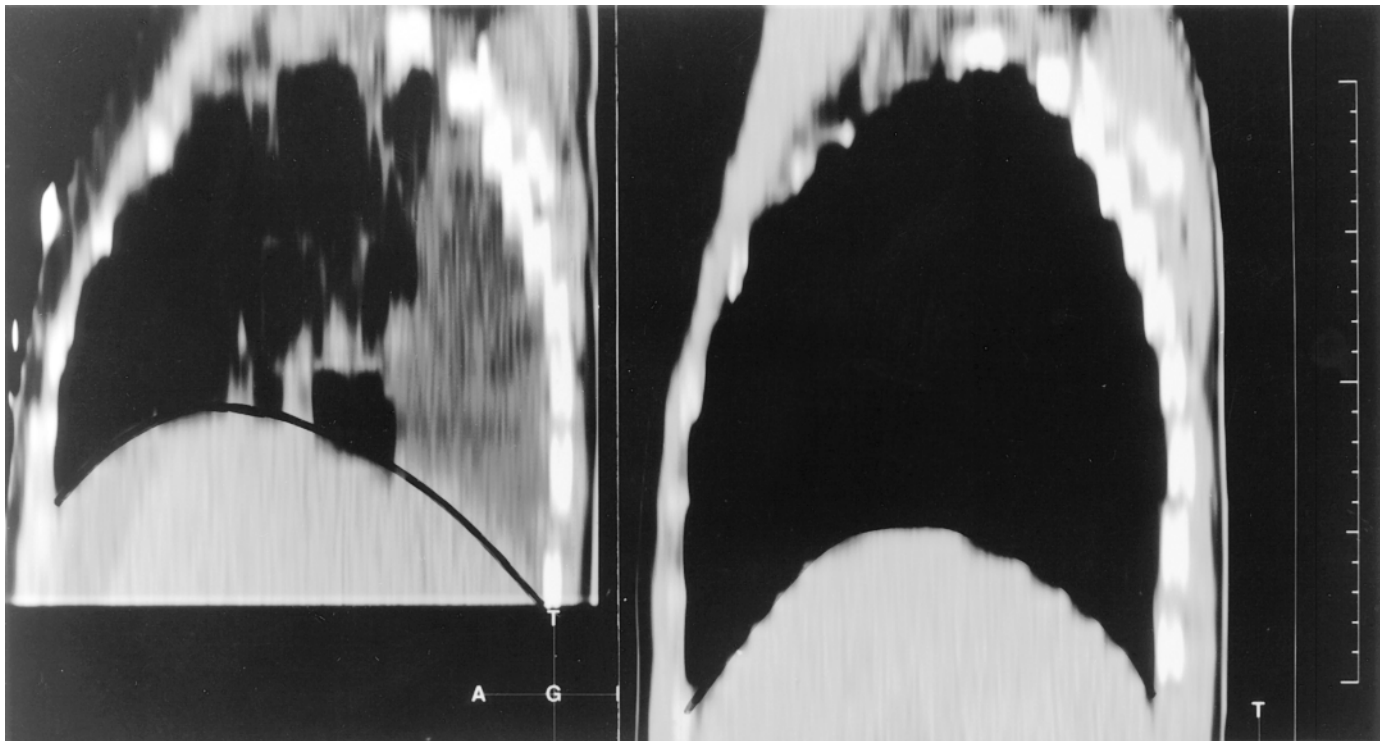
Sagittal reconstructions of the right lung (mediastinal windows) obtained from the contiguous CT sections in one patient with acute lung injury (*left side*) and one healthy volunteer (*right side*). The centimetric scale on the right side has a height of 20 cm.
